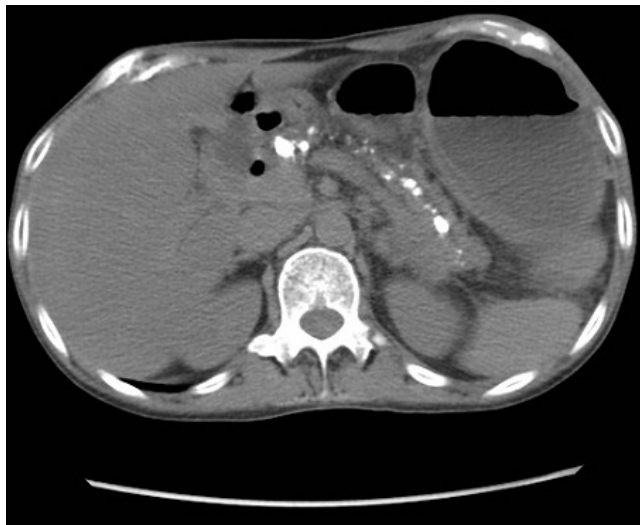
CT scan of abdomen showing calcification within the pancreatic parenchyma and dilatation of duct with calcification within the pancreatic duct. White arrow denoting calcification within the pancreatic duct resulting into its dilatation.
